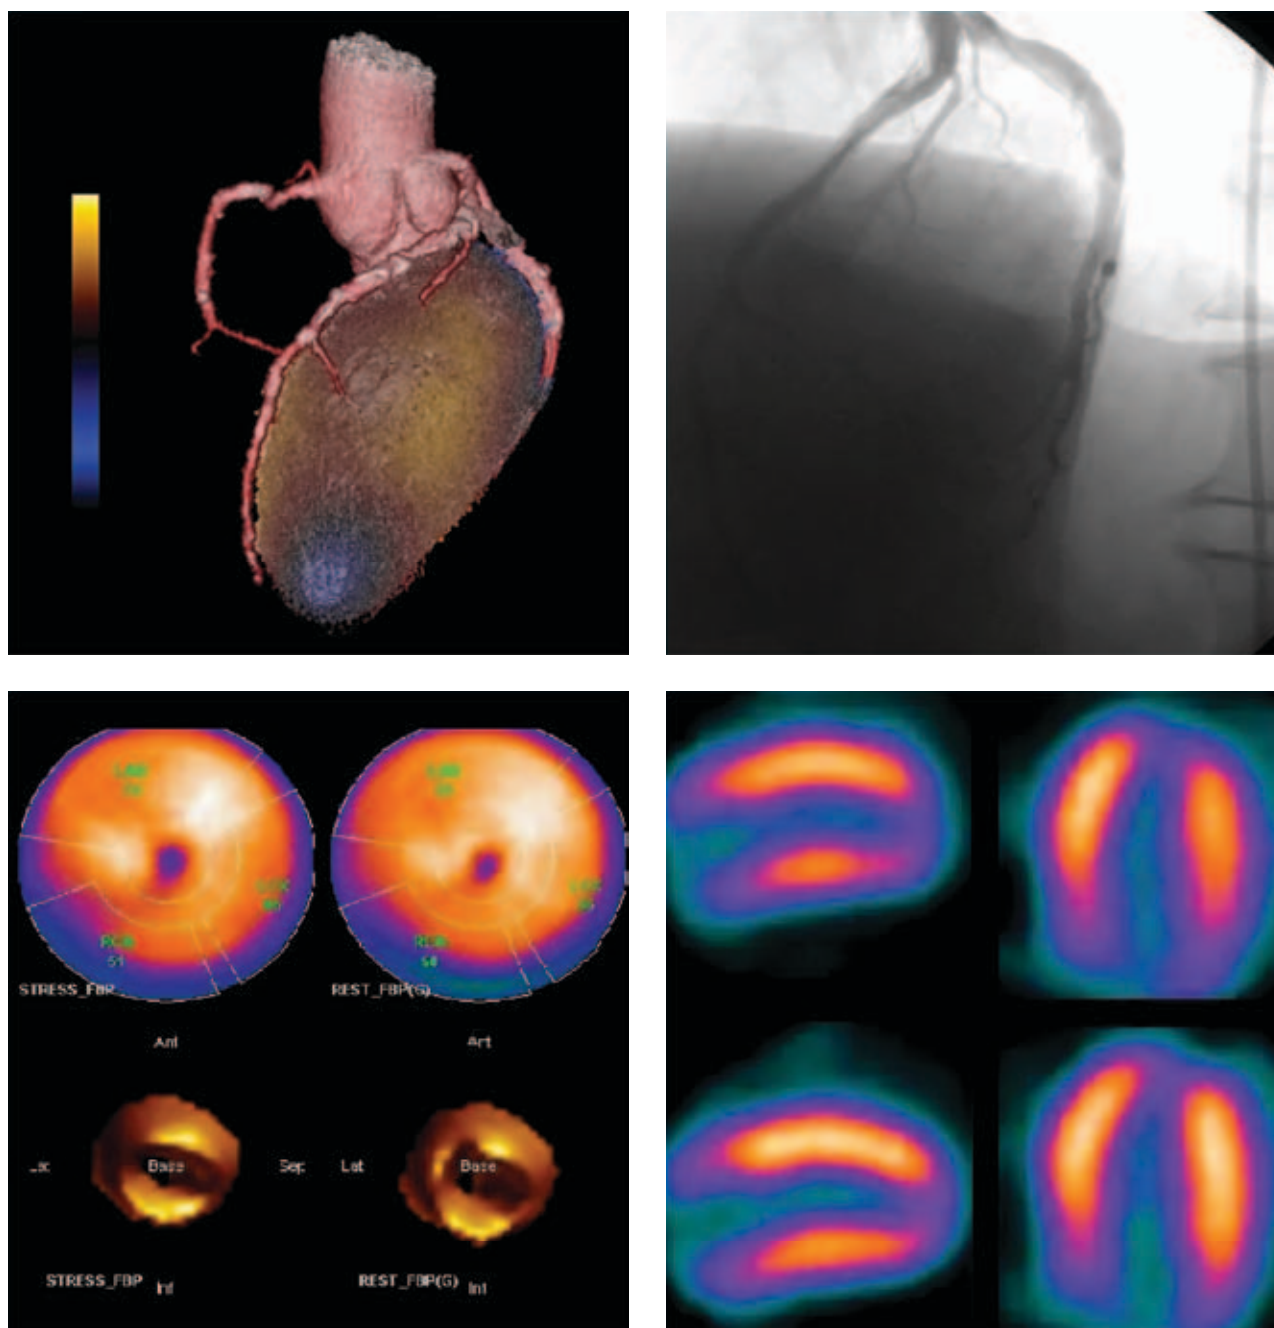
Example of a 59-year-old man with a history of a “cardiac event” in the past. Upper left panel: fusion imaging with atherosclerotic lesions in all 3 vessels and occlusion of the second diagonal artery, whose distribution shows an apical perfusion defect. Upper right panel: conventional coronary angiography confirms the finding. Lower panel: quantitative and qualitative results of the SPECT study are consistent with the above.
